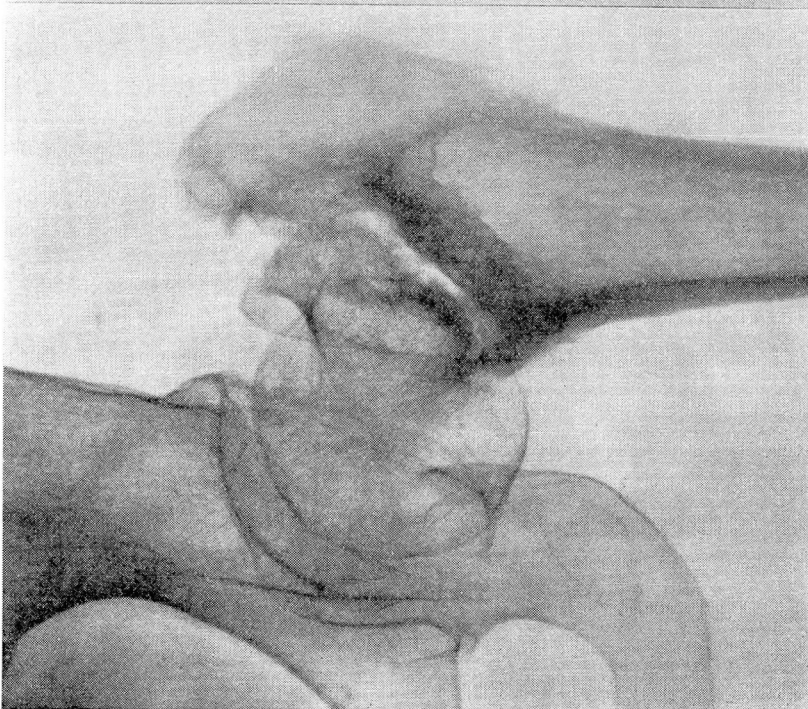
Case 2. Roentgenogram showing ununited fracture before operation.
